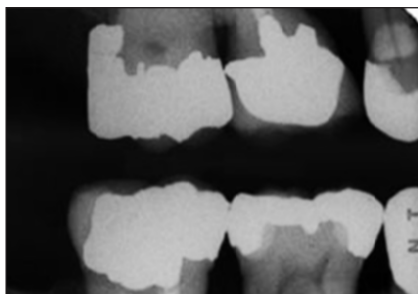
Preoperative radiographic image of tooth #2 with bulky distal overhang.
